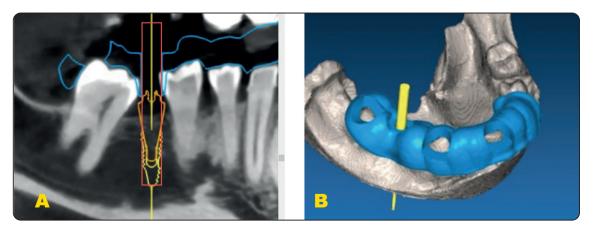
Shows surgical guide planning and design using data obtained from CBCT and scanned impression. A) shows implant position, B) shows surgical guide design
